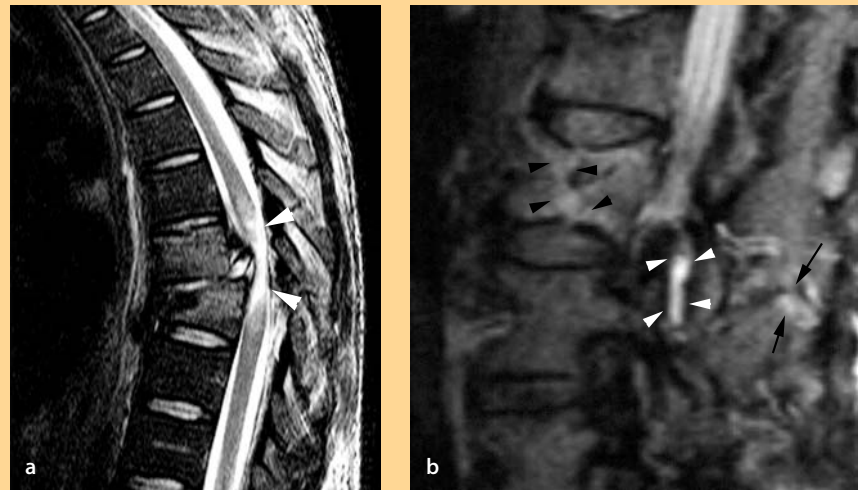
MRI fracture assessment
